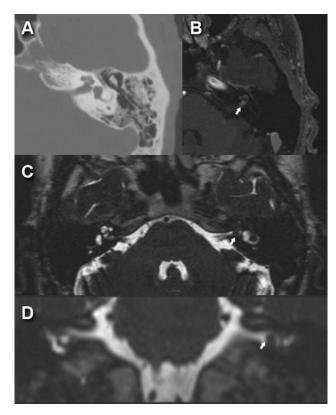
Preoperative radiologic evaluation. (A) At computed tomography (CT) scan, no obvious erosions involving the inner ear or internal auditory canal were evident. (B) Axial T1-weighted MR images, showing the neoplasm, involving the cochlea and internal auditory canal in its most lateral portion. The mass is hyperintense and is slightly enhanced by gadolinium (arrow). (C) Axial T2-weighted MR images. The mass appears hypointense to muscle (arrow). (D) Coronal T2-weighted MR images. The involvement of the internal auditory canal by the small mass is highlighted (arrow).
